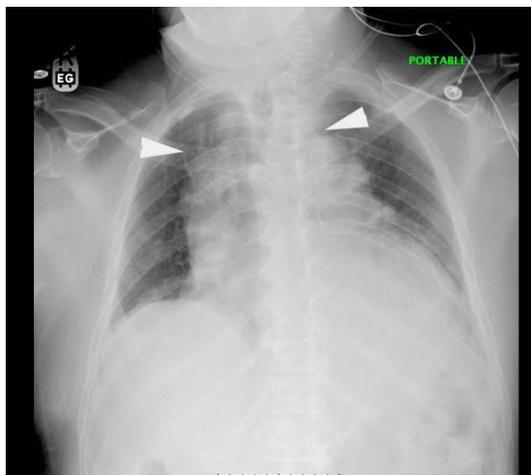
Chest X-ray with widened mediastinum
